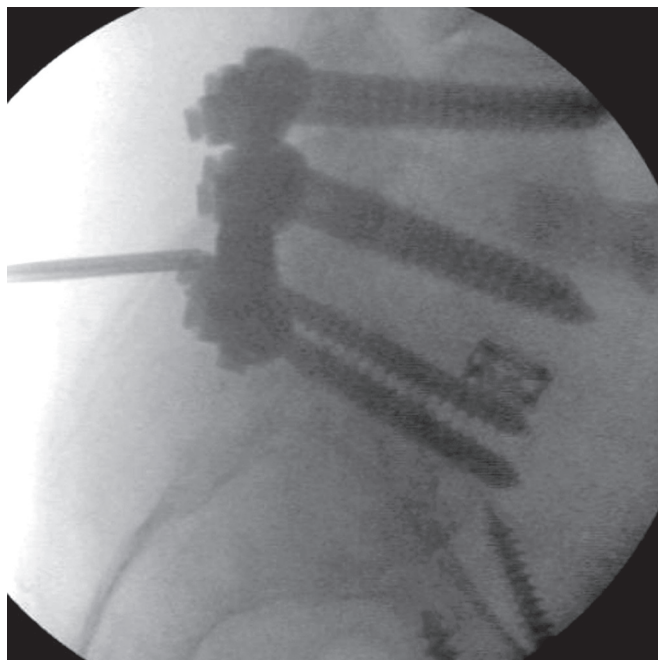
X-rays of lumbar fusion—Lateral view
